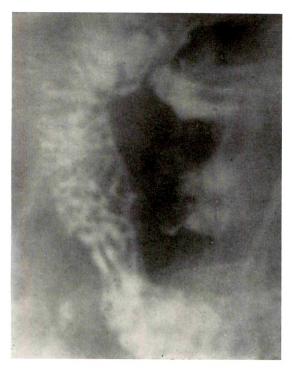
Case II. Spot roentgenogram of the duodenal sweep with oral contrast material, which also outlines the diverticulum.
